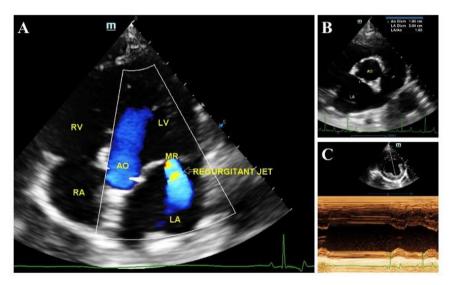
Color Doppler echocardiography shows turbulent flow in the left atrium during systole (A). Two-dimensional view of the left atrium and aorta on the right parasternal short axis view (B). Two-dimensional and M-mode echocardiography shows the left ventricular internal diameter on the right parasternal short axis view at the level of the head of the papillary muscle (C). LV=left ventricle; RV=right ventricle; RA=right atrium; LA=left atrium; Ao=aorta; MR=mitral regurgitation
